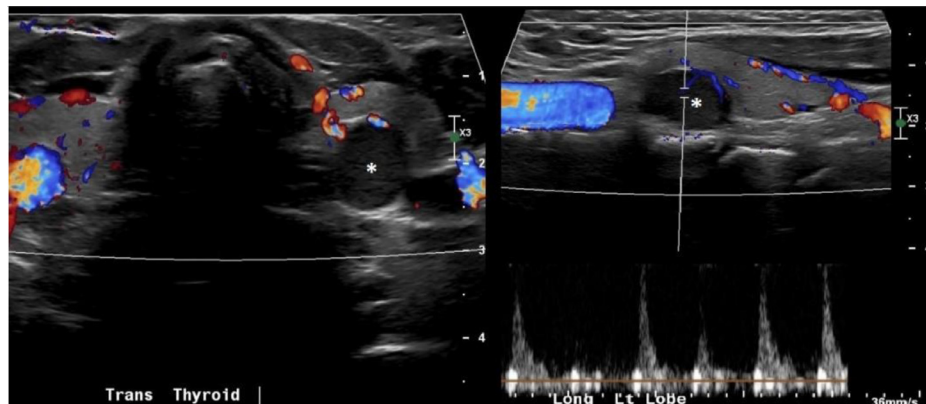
Neck ultrasound (US) demonstrates a vascular hypoechoic, homogeneous solid nodule that measures 1 x 1.4 x 0.9 cm posterior to the mid pole of the left thyroid gland (asterisk).
